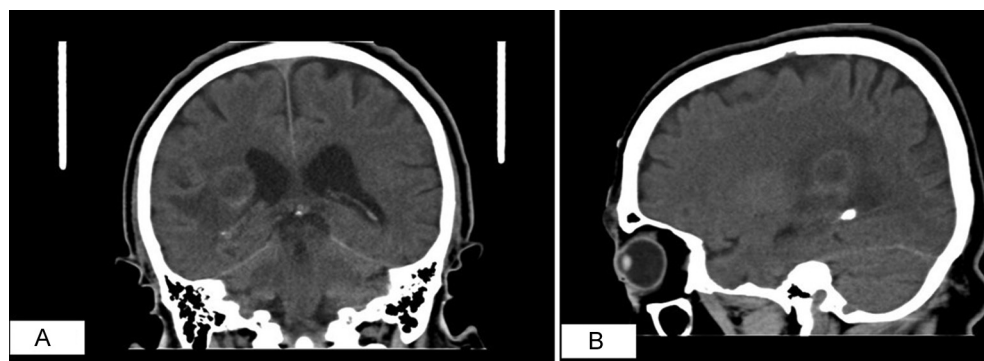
(A) CT scan coronal plane showing brain abscess surrounded by vasogenic oedema. (B) CT scan sagittal plane showing brain abscess surrounded by vasogenic oedema. (A,B) CT scan showing brain abscess surrounded by vasogenic oedema.
